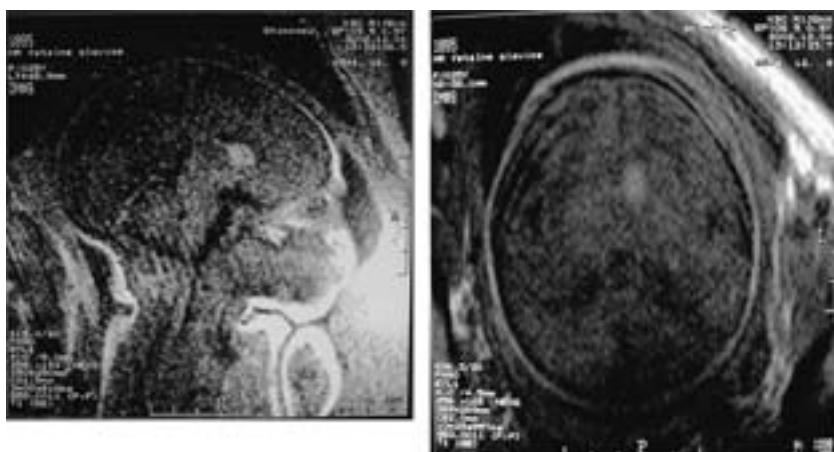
Brain hamartomas identified by fetal cranial MRI at the 36th gestational week
